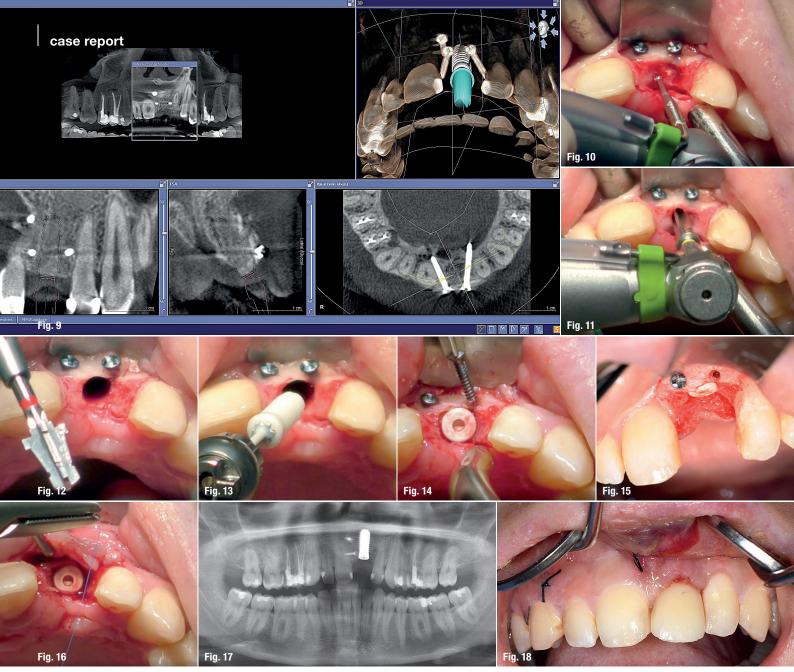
CBCT after the bone regeneration procedure. Figs. 10–12: The osteotomy was prepared by means of a rose drill. Figs. 13 & 14: The implant was inserted and covered with a healing cap. Figs. 15 & 16: One of the three osteosynthesis screws was removed, and the soft tissue was sutured. Fig. 17: Radiograph taken after the implant surgery. Fig. 18: View of the removable restoration.
